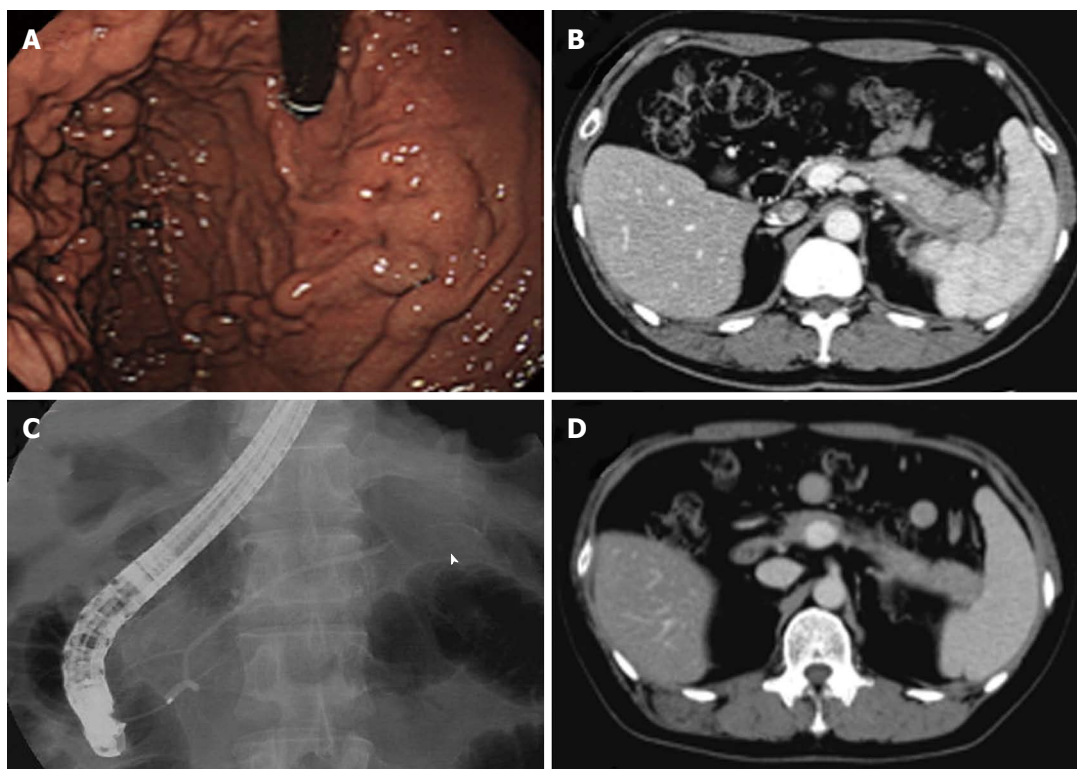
The splenic vein was not reperfused, although the autoimmune pancreatitis improved. A: Esophagogastroduodenoscopy showed gastric varices in the fundus of the stomach; B: Computed tomography showed a locally enlarged pancreatic tail with a capsule-like rim, an obstructed splenic vein, and splenomegaly; C: Endoscopic retrograde cholangiopancreatography showed irregular narrowing of the main pancreatic duct in the pancreatic tail (arrowhead); D: Autoimmune pancreatitis improved following steroid therapy, but the splenic vein was not reperfused.
